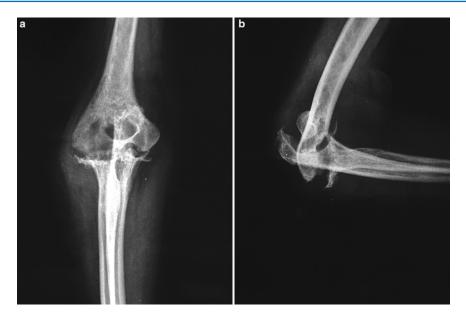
(a, b) Homolateral TEA and TWA. Right elbow preoperative X-rays
